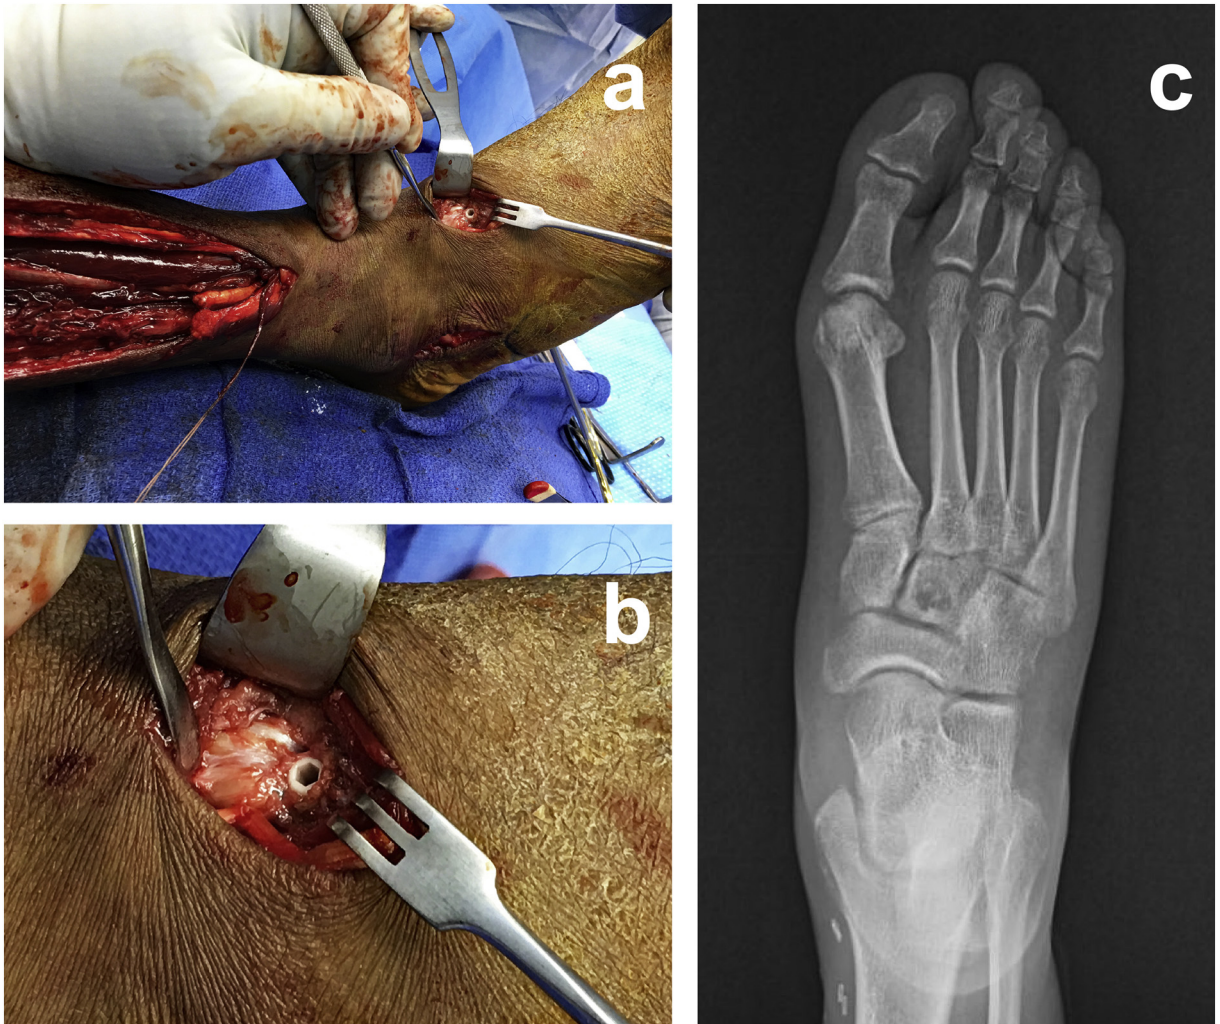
(a and b) Intraoperative view of the insertion of the posterior tibialis tendon in the second cuneiform using an interference tenodesis screw. (c) X-ray image shows the location of the hole in the second cuneiform.
